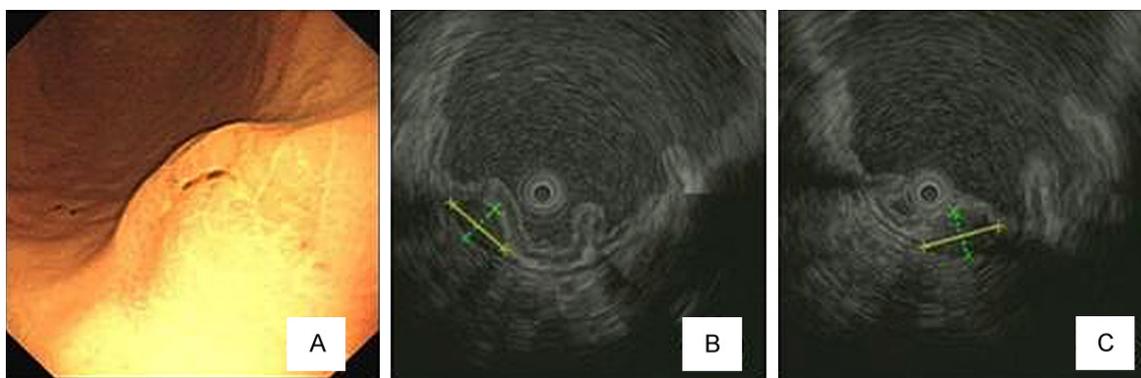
Endoscopic and EUS finding of gastric heterotopic pancreas that was misdiagnosed as a gastric stromal tumor. (A) The lesion was located in the gastric body and did not have an umbilicate pit with an opening on the surface. EUS findings (B) within muscularis, hypoechoic, homogeneous, well-demarcated. EUS findings (C) within muscularis, hypoechoic, inhomogeneous, unclear border. It reminded us that we should observe more cross-sections carefully under ultrasound.
